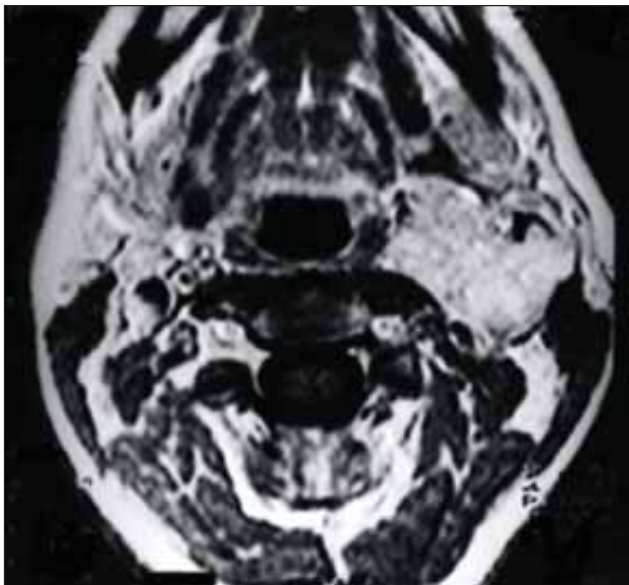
(first patient). glomus tumor of the left carotid body. MRI features: axial T1 after Gadolinium; cervical mass widening the carotid bifurcation, with intense enhancement. Typical "salt and pepper" aspect due to the serpentine areas of signal-void
